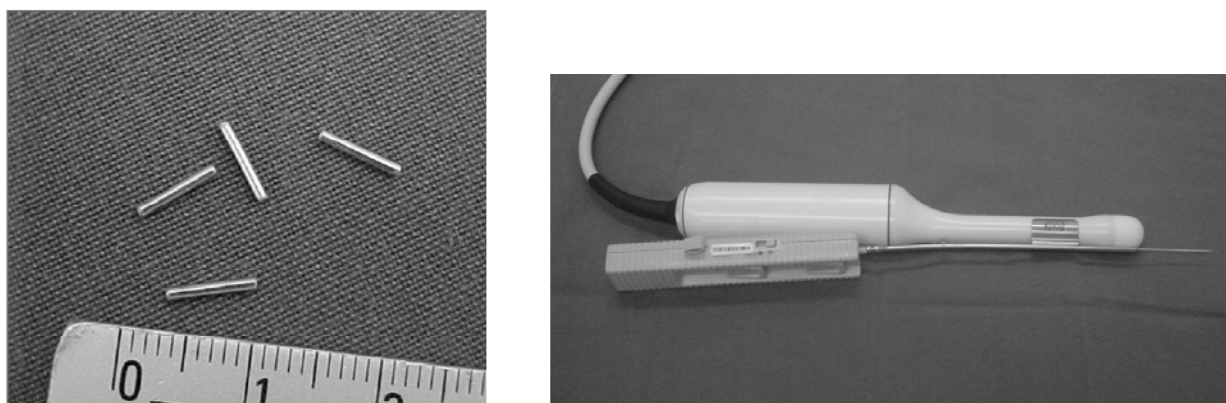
(a) Fine gold fiducial prostate markers. (b) Prostate biopsy tool used for marker implantation, mounted on ultrasound probe.
